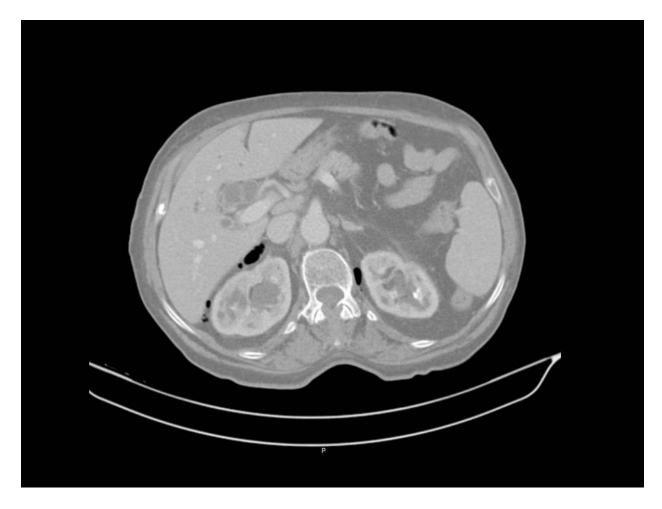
Duodenal perforation after endoscopic retrograde cholangiopancreatography. CT scan shows retroperitoneal air bubbles, as in the right and left perirenal spaces.
